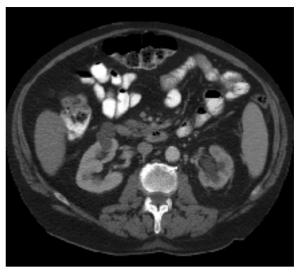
Atrophic left kidney. Noncontrast CT demonstrating left hydronephrosis and renal atrophy in patient with distal ureteric obstruction
